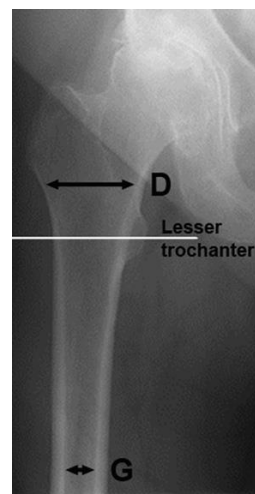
Canal flare index is calculated from radiographs as the ratio of D to G, where D is the width 20 mm proximal to the most prominent point of the lesser trochanter and G is the width of the femoral isthmus.
